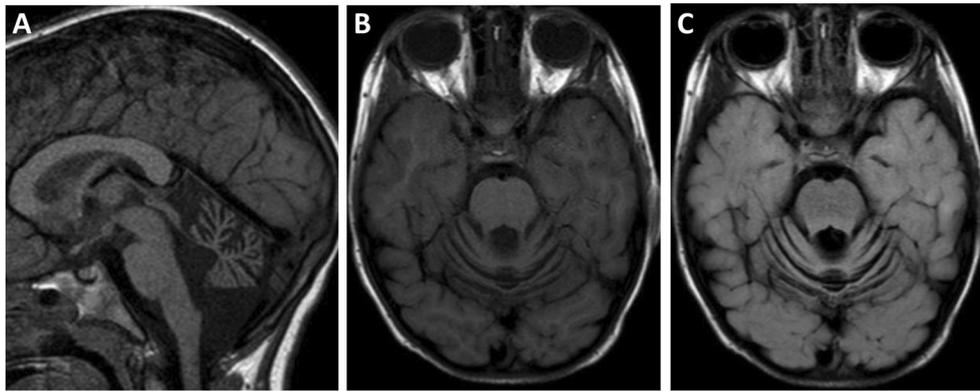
Neuroimaging at the age of 40 months. (A) Sagittal T1-weighted image demonstrating markedly enlarged fissures of the cerebellar vermis and preserved pontine protuberance. (B) Axial T1-weighted image showing enlarged fissures in vermis and cerebellar hemispheres. (C) Axial FLAIR sequence with evidence of mild hyperintensity of the cerebellar cortex (compared with cerebral cortex). FLAIR, fluid-attenuated inversion recovery.
